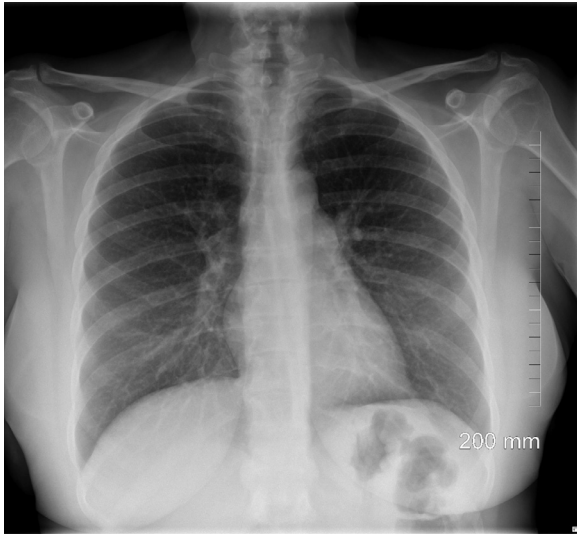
postero-anterior chest radiograph showing normal appearances of the lung parenchyma, heart, mediastinum and bony structures.
